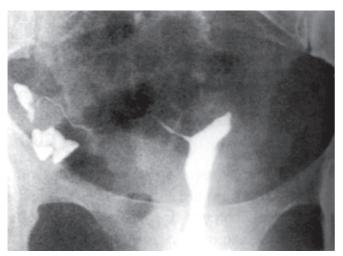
Rotation of the normal uterus as revealed by hysterography. The degree of twist is not of significance but radiographs showing this sort of picture are often misinterpreted as showing a uterine malformation
